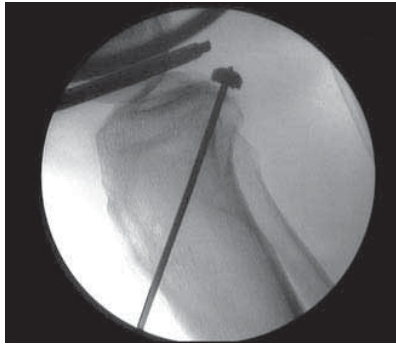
Radiographic lateral view of a tibial drill for the arthroscopic inlay technique.
